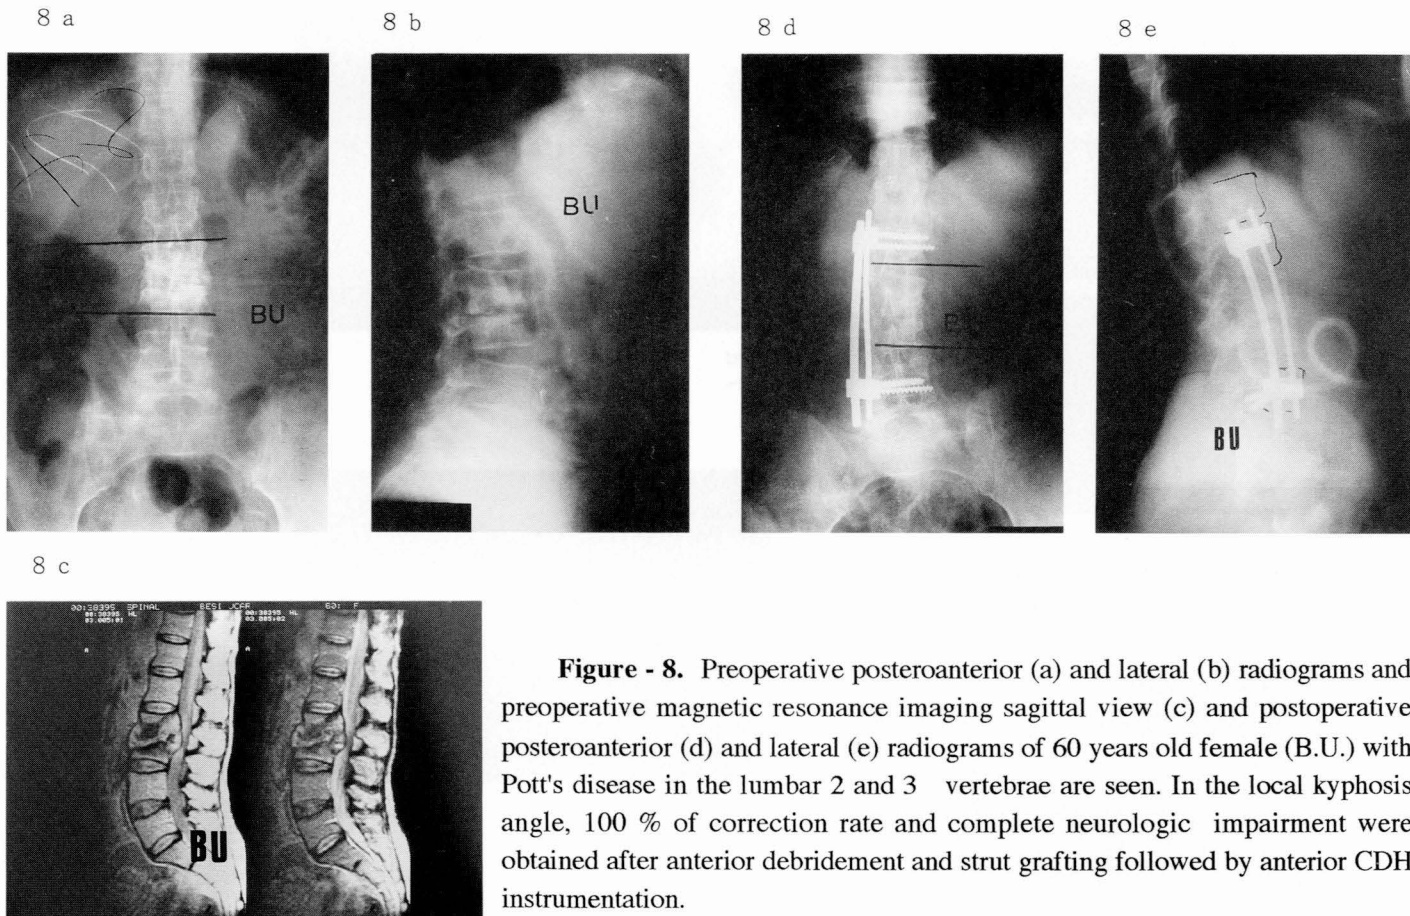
Preoperative posteroanterior (a) and lateral (b) radiograms and preoperative magnetic resonance imaging sagittal view (c) and postoperative posteroanterior (d) and lateral (e) radiograms of 60 years old female (B.U.) with Pott's disease in the lumbar 2 and 3 vertebrae are seen. In the local kyphosis angle, 100 % of correction rate and complete neurologic impairment were obtained after anterior debridement and strut grafting followed by anterior CDH instrumentation.
